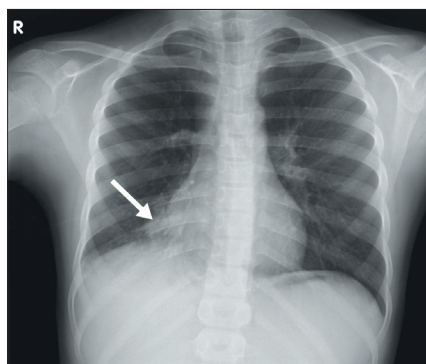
Chest X-ray showing fine bilateral infiltrates.
